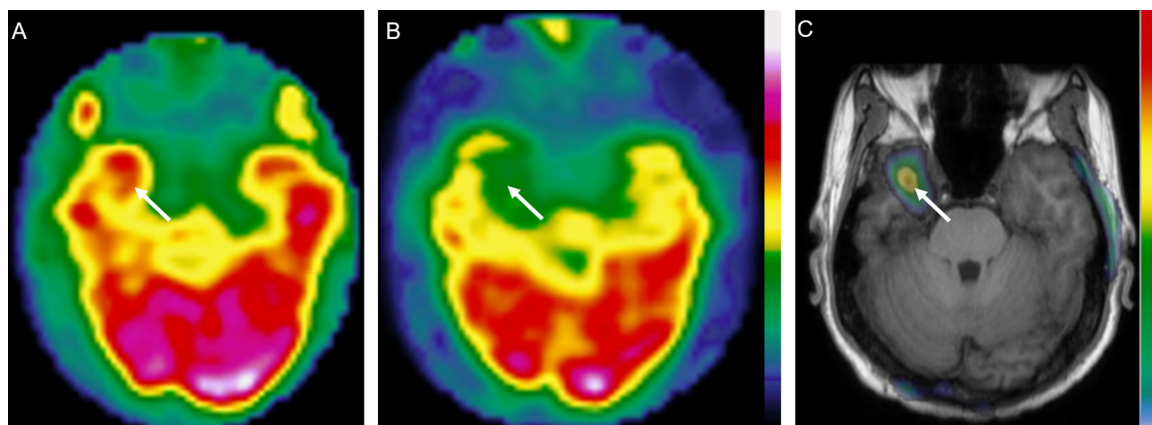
Axial views of perfusion SPECT imaging from a 40-year-old man with right temporal epilepsy in (A) ictal and (B) interictal phases, and (C) after subtraction of ictal and interictal SPECT images co-registered to MRI (SISCOM). Hyperperfusion is evident in the right mesial temporal area (A, white arrow), which is hypoperfused in the interictal state (B, white arrow). Subtraction of ictal and interictal states reveals a significant perfusion differential in the same area (C, white arrow), corresponding to the right mesial temporal lobe on SISCOM.
